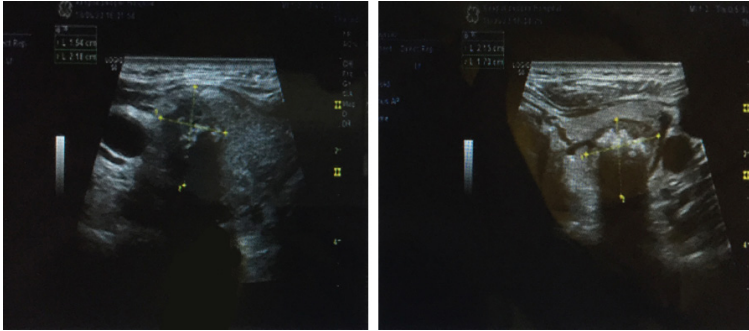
Ultrasound showed the dominant nodules in the bilateral right and left thyroid lobes: the diameter of the largest nodule was 1 cm in left lobe and 2 cm in right lobe.
